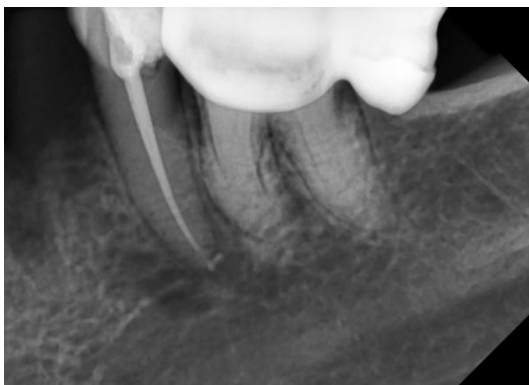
Obturation radiograph
